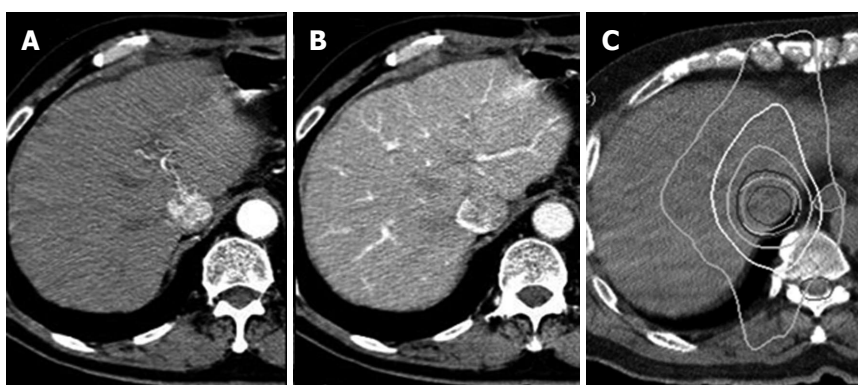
Hepatocellular carcinoma case that could not be effectively or safely treated with any treatment except for stereotactic body radiation therapy. The tumor invading the vena cava is enhanced in arterial phase and shows a defect in portal phase on dynamic computed tomography (A and B). An axial view of radiation dose distribution. The isodose lines (white lines) from inner to outer represent 40, 30, 20, and 10 Gy, respectively (C).
